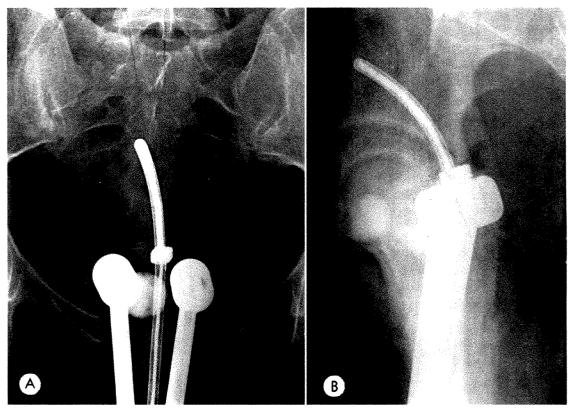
(d) Anteroposterior and (B) lateral roentgenograms of an intracavitary implant of Fletcher cervical applicators. The applicators are loaded with 15+10+10 mg. radium tubes in the uterine tandem and 20 + 20 mg. radium tubes in the vaginal colpostats. The sources are 1.5 cm. active length with 1.0 mm. platinum filtration.
